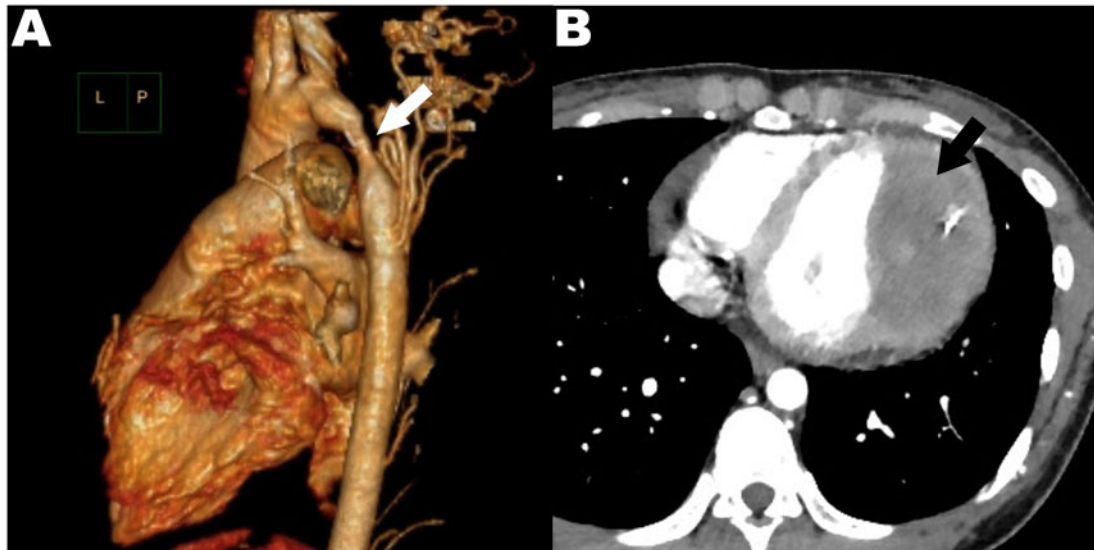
The aortic computed tomography angiography revealed a post-ductal-type coarctation of the aorta (white arrow) at the beginning segment of the descending aorta accompanied by multiple collateral vessels, presenting from a left posterior oblique view (A), and a 77 mm × 51 mm large cardiac mass with a compressed left ventricular chamber (black arrow; B).
